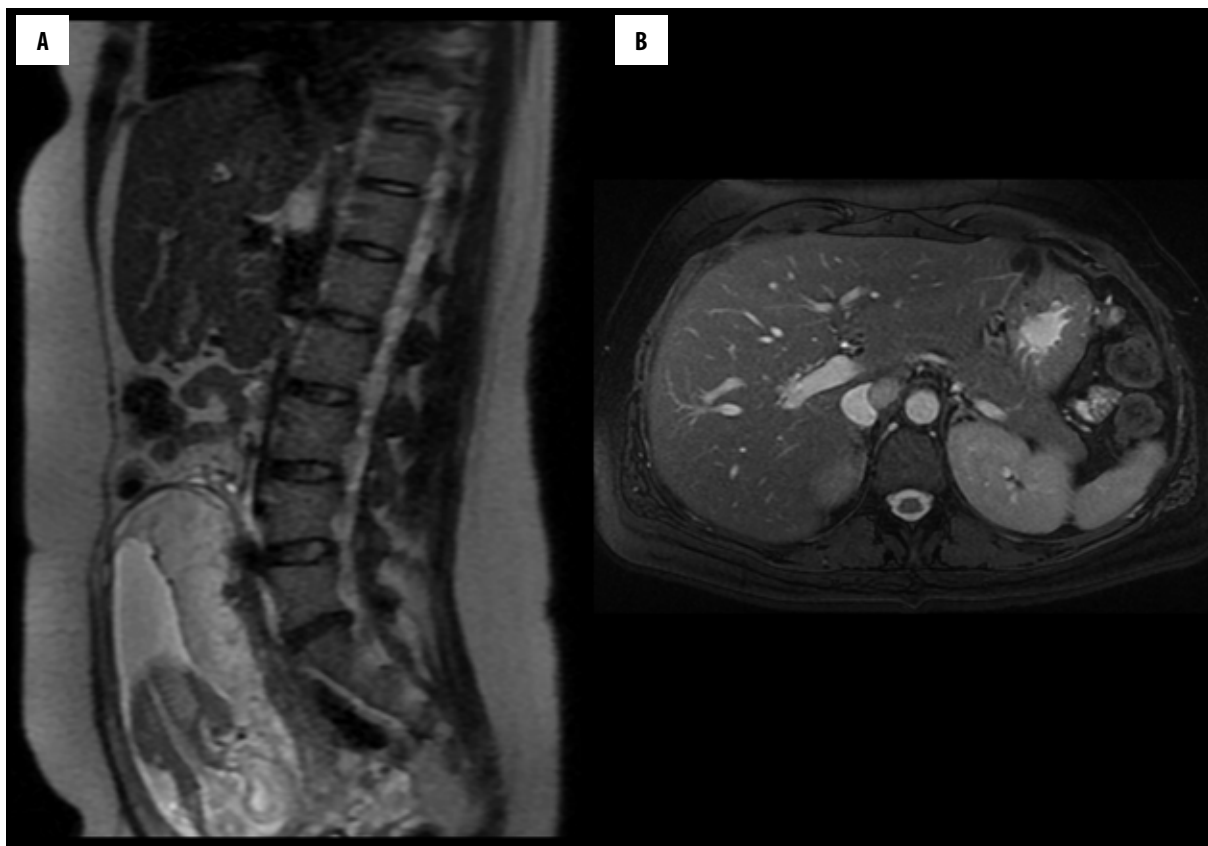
Pheochromocytoma with high-intensity signal in T2-weighted images in the periaortal area in a pregnant patient (week 19 of gestation) (A). Axial view, the inferior vena cava is modeled by the tumor (B). The patient underwent surgery during pregnancy.
